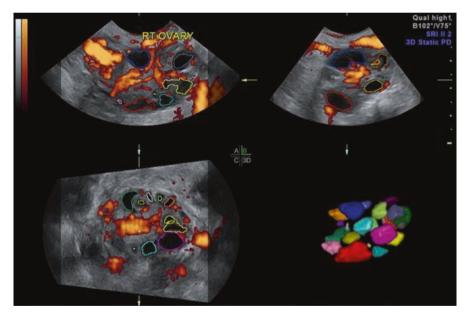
3D ultrasound volume of the ovary showing sectional planes and the lower right image shows colour-coded follicles on SonoAVC
